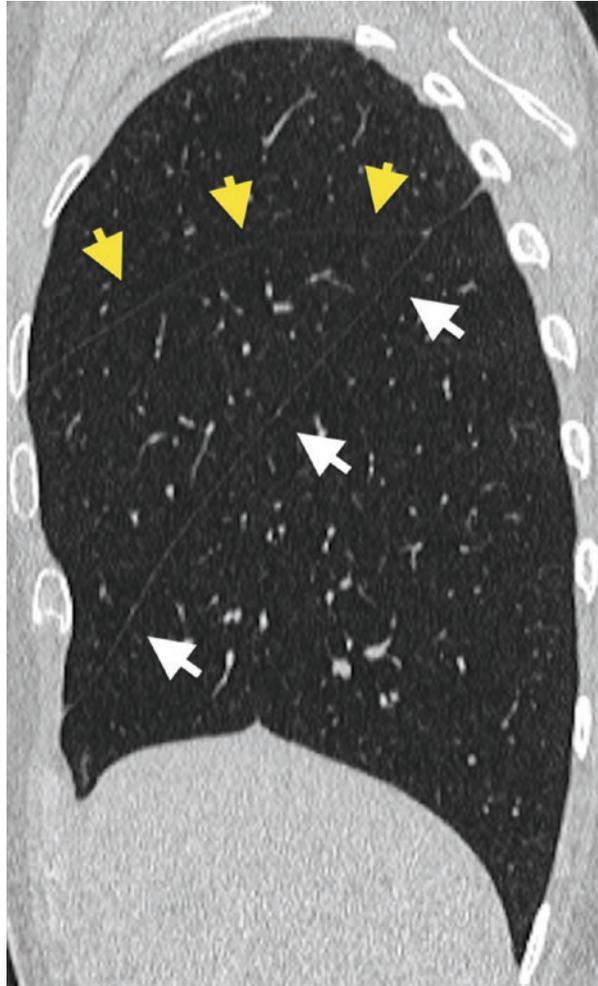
CT scan, left lung lobe—The major fissure, or oblique fissure, (*white arrows*) originates in the superior portion of the hilum, runs upwards and backwards, passes the posterior margin, crosses the lateral surface, and descends obliquely up to the base. Then, it crosses the base and continues on the medial surface to end in the inferior part of the hilum
